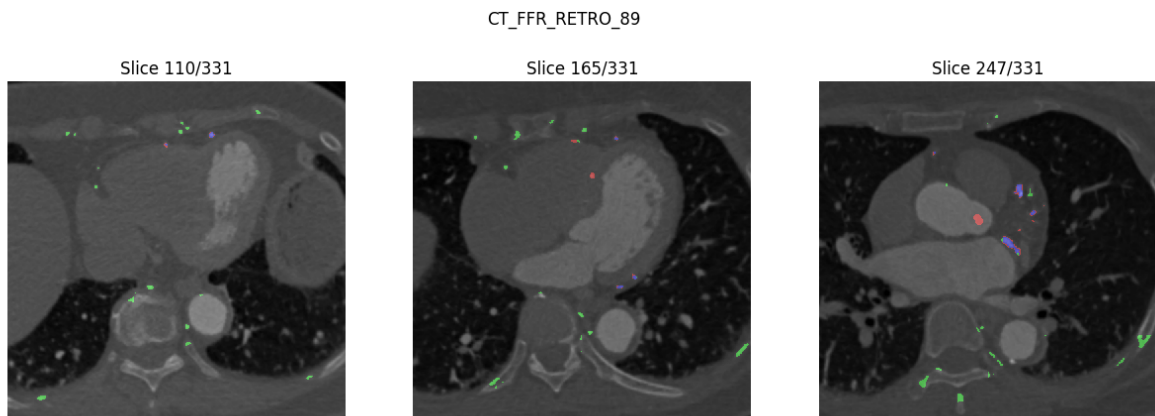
A selection of some of the CT slices of the BVNet3D model's worst prediction of the coronary artery split-1, where the corresponding prediction is overlaid. The prediction is color-coded with blue=TP, green=FP, and red with low opacity=FN
